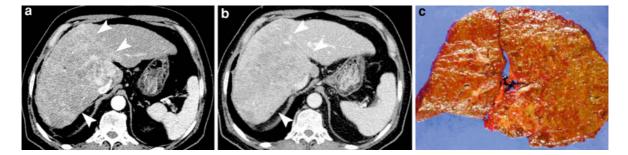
Diffuse HCC. a Arterial phase CT scan shows a very heterogeneously enhancing right hepatic lobe (*arrowheads*). b Portal phase CT scan shows an inhomogeneous hypoattenuation
